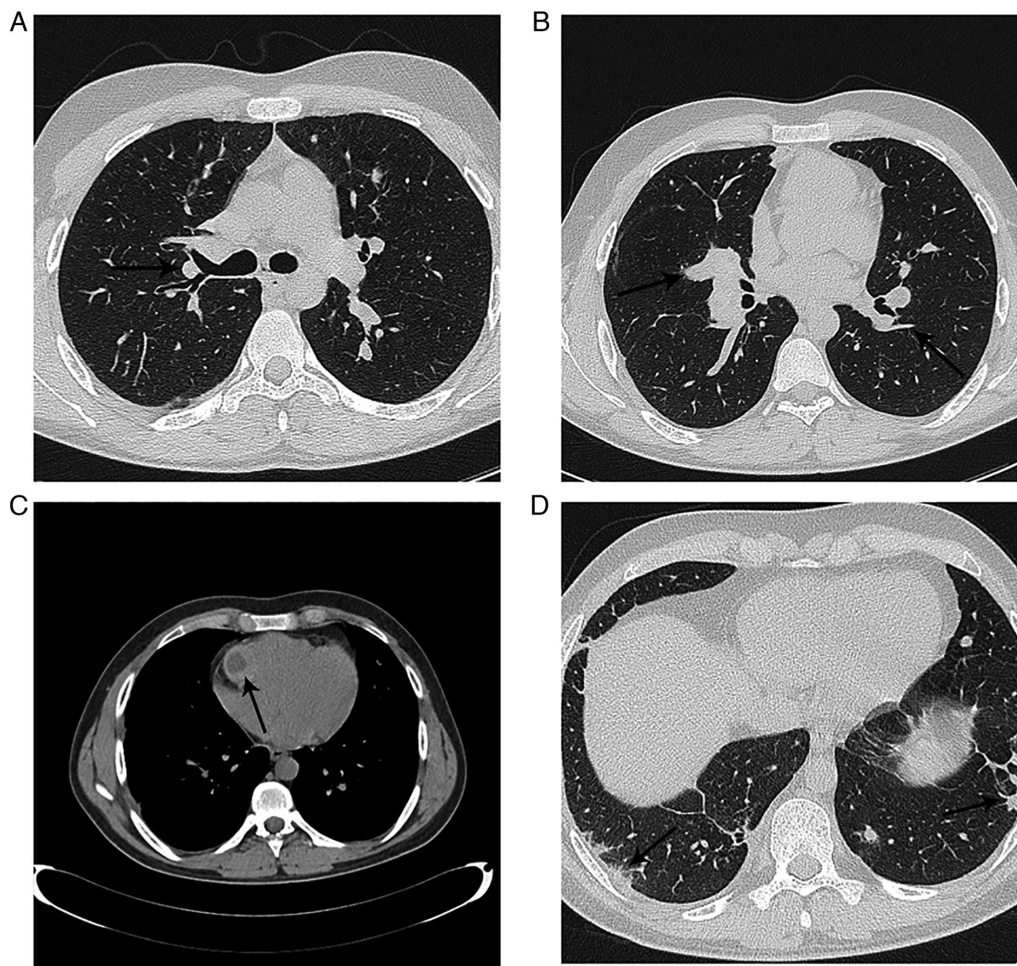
Pulmonary CT scan presenting (A) bilateral central pulmonary nodules, (B) a bilateral pulmonary embolism of the segmental arteries, (C) a mass on the right ventricle free wall and (D) subpleural pulmonary nodules.
